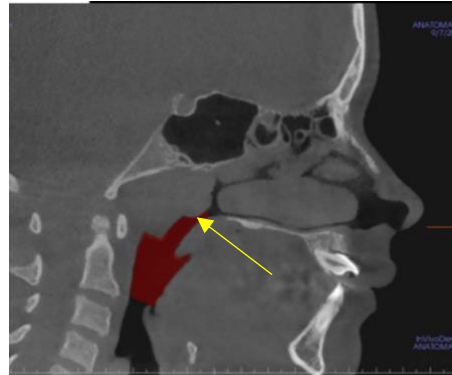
CBCT sagittal cross-section demonstrating adenoid hypertrophy leading to a narrowed airway
